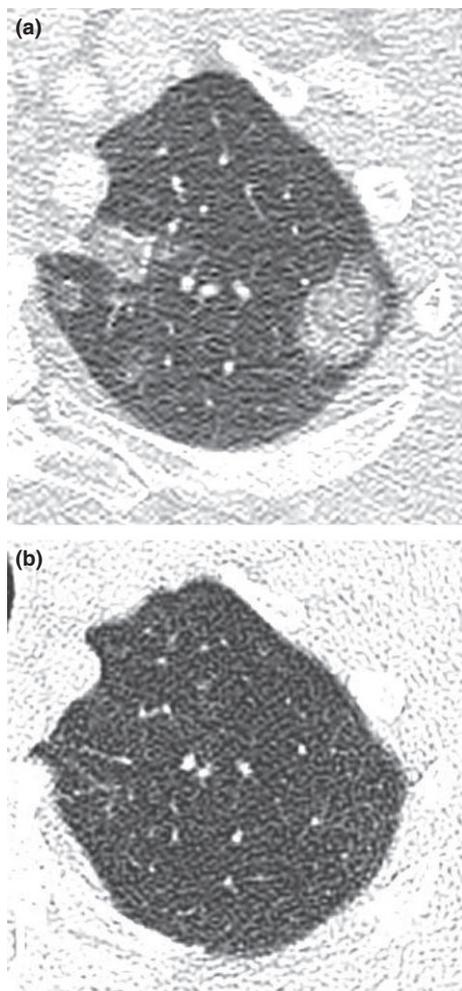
CT scan with ground-glass infiltrate in the left-sided upper pulmonary lobe in 11/2010 (a) and successive normalization after therapy in 07/2011 (b).
